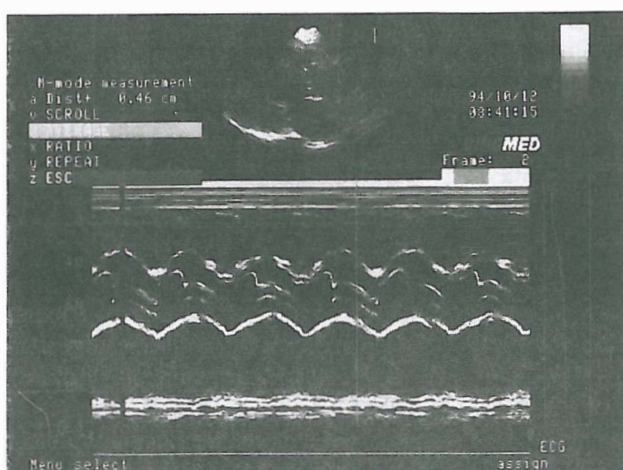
M-mode echocardiogram shows thickened aortic valve cusps with incomplete diastolic coaptation.
